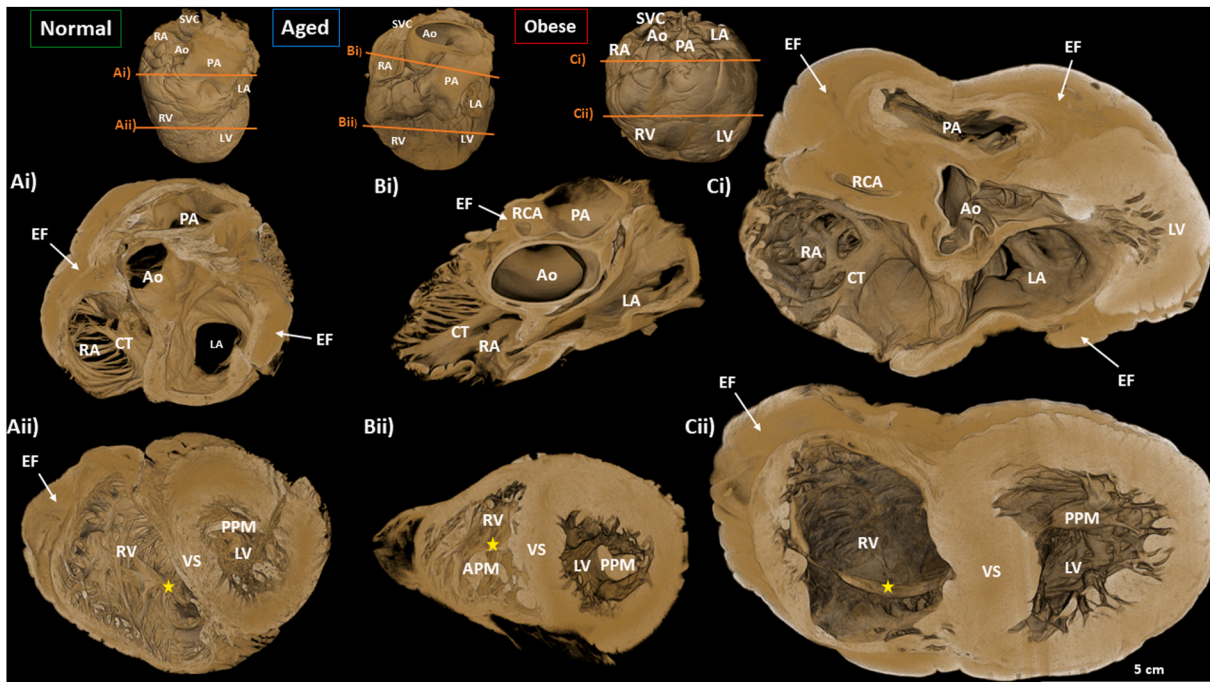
Short axis views of the internal structures of the normal, aged and obese hearts. A, normal heart. B, aged heart. C, obese heart. Ai, Bi, Ci base view looking into the atrial chambers. Aii, Bii, Cii apex view looking into the ventricular chambers. The view point locations in A, B, C is indicated by the orange lines in the volume rendering in the top panels. The yellow stars indicate the moderator band. APM = anterior papillary muscle; Ao = aorta; CT = crista terminalis; EF = epicardial fat; LA = left atrium; LV = left ventricle; PPM = posterior papillary muscle; RA = right atrium; RV = right ventricle; VS = ventricular septum. (For interpretation of the references to colour in this figure legend, the reader is referred to the Web version of this article.)
